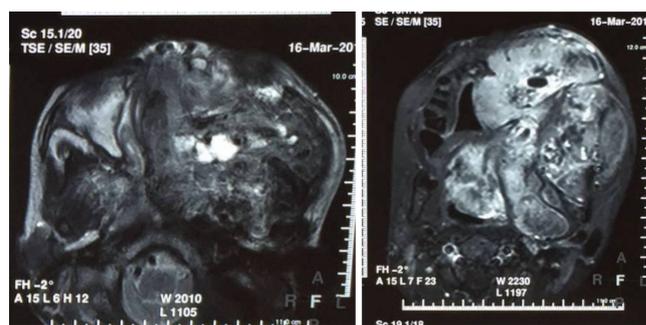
Pre contrast multiplanar MRI; Figure-6: Post contrast multiplanar MRI
